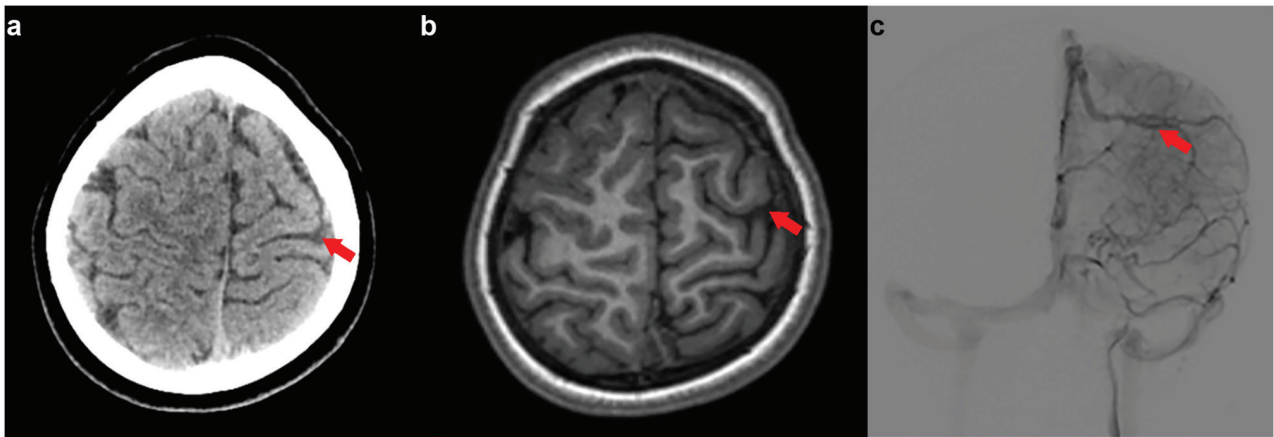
Brain MRI showcasing the discrepancy in size between the left and right frontal-parietal lobe. (a) Discrepancy in size between the left frontal-parietal lobe and its right counterpart on skull MRI. (b) Visualization of left pia mater and venous malformations. (c) Evidence of localized structural asymmetries and abnormalities. The red arrow indicates the lesion.
